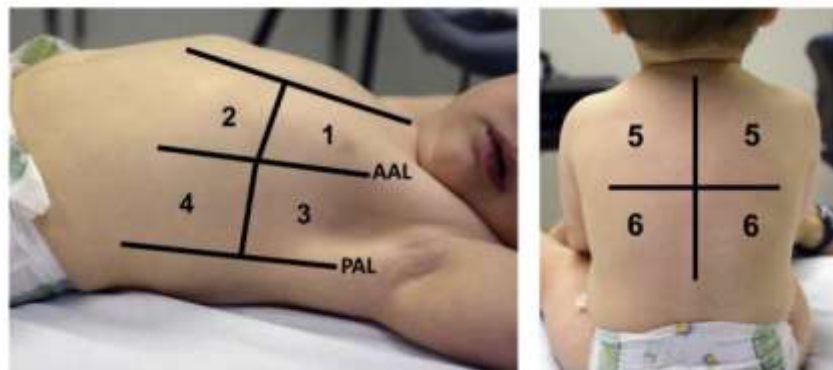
Areas of thoracic region to be scanned by ultrasound (*Ambroggio et al., 2016*)
